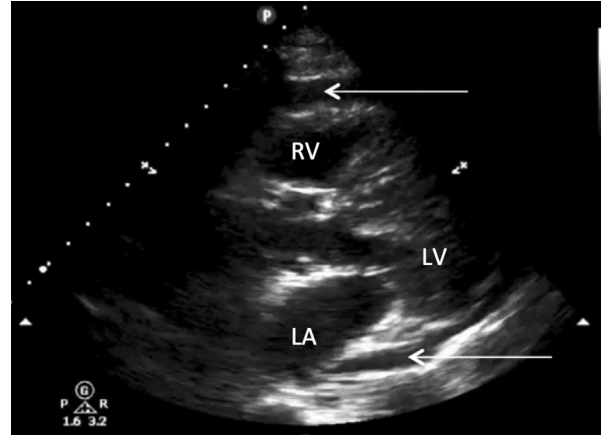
Parasternal long axis: thin arrow indicates anterior and posterior pericardial fluid. LA = left atrium; LV = left ventricle; RV = right ventricle.
